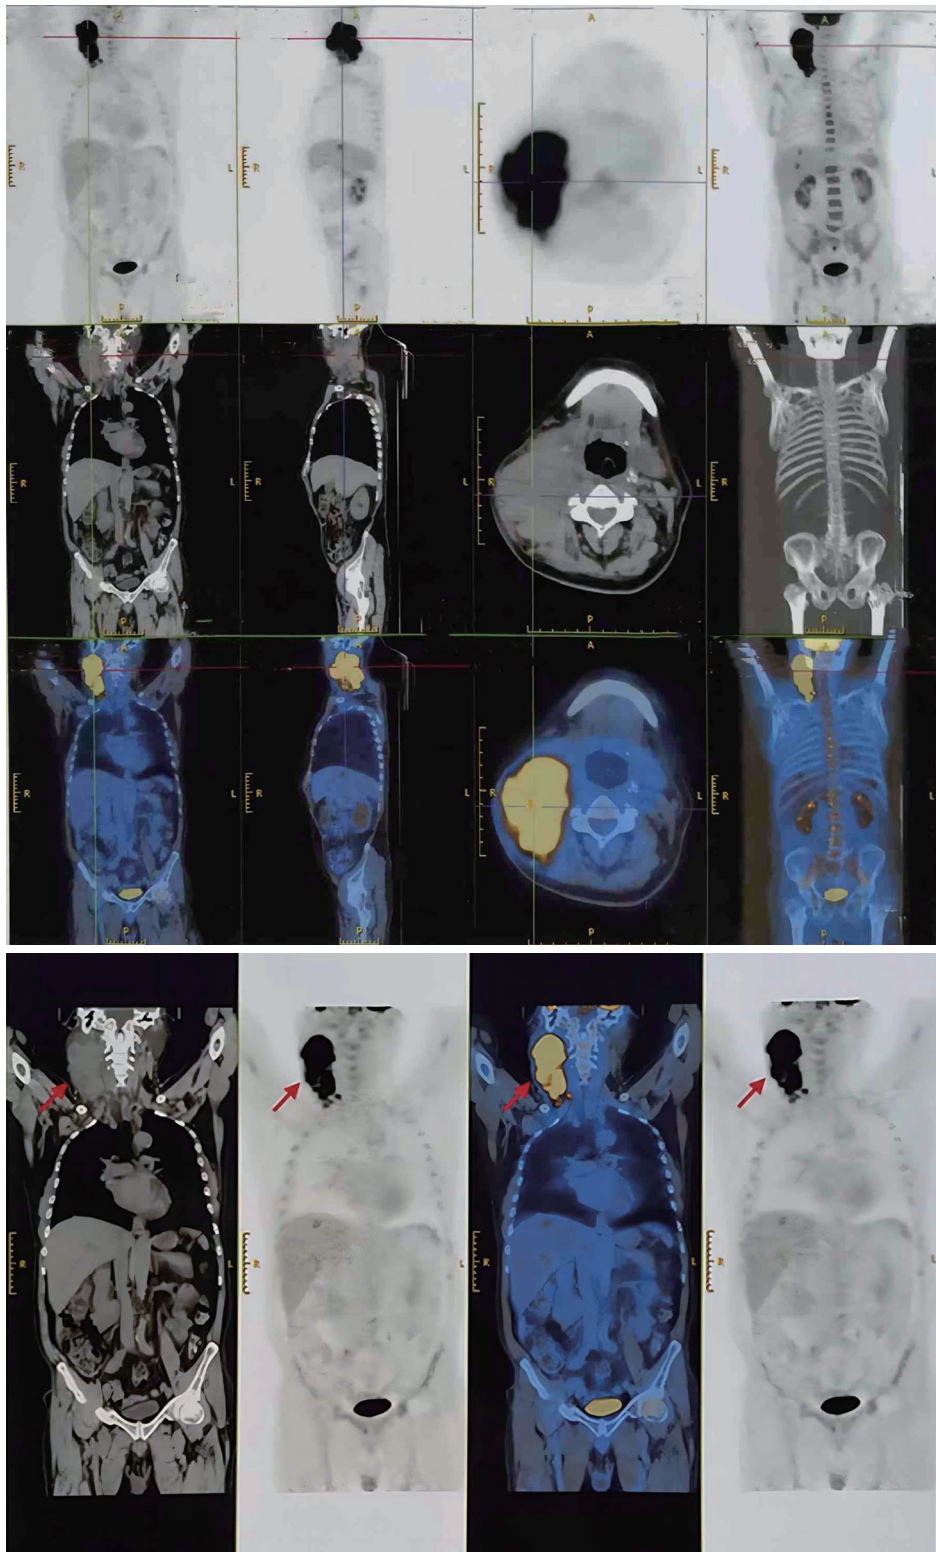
Positron emission tomography-computed tomography imaging performed on February 22, 2022 revealed the involvement of the lateral and supraclavicular lymph nodes on the right side of the neck, with evidence of increased fluorodeoxyglucose uptake. The arrows on the second picture are pointing to the malignancy with high fluorodeoxyglucose uptake.
